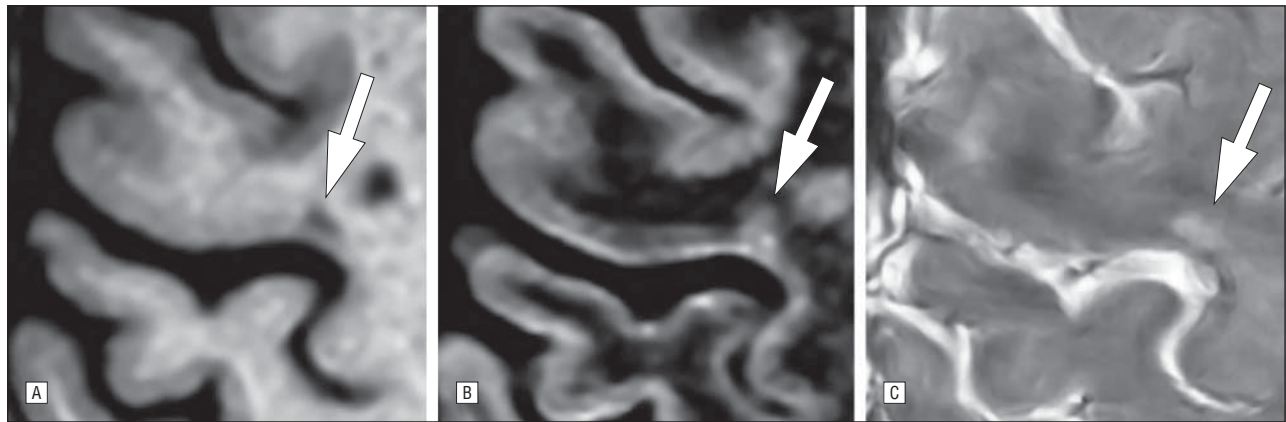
Comparison of cortical lesion detection and classification using 3- and 7-T magnetic resonance imaging. A and B, Three-Tesla T1-weighted magnetization-prepared rapid acquisition with gradient echo (A) and double inversion recovery (B) sequences disclosed a juxtacortical lesion (arrow). C, Seven-Tesla fast low-angle shot-T2*-weighed imaging categorized the lesion as type 1 (arrow). Adapted from Nielsen et al²⁰ with permission.
